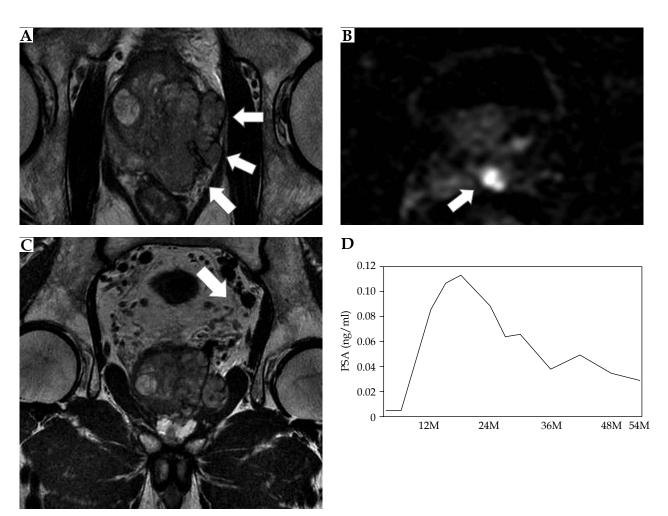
Representative T3bN1 case treated by tri-modality with whole pelvis external beam radiotherapy (EBRT). Case: 68-year-old man with initial prostate-specific antigen (PSA) 65 ng/ml. The needle biopsy Gleason's score was 4+4. Clinical stage was T3bN1. Magnetic resonance imaging shows (A) a bulky prostate tumor extending over the capsule and compressing the rectal wall (B) with seminal vesicle invasion, and (C) nodal metastasis as indicated by white arrows. The patient was treated by combination therapy with low-dose-rate (LDR) brachytherapy, whole pelvis EBRT, and androgen deprivation therapy (ADT). Upon seeds implantation, they were implanted in seminal vesicle as well as prostate [15]; (D) PSA change after treatment: PSA shows temporal increase after cessation of ADT, but continuous decrease was observed thereafter. Y axis shows the period (months) from completion of the EBRT
